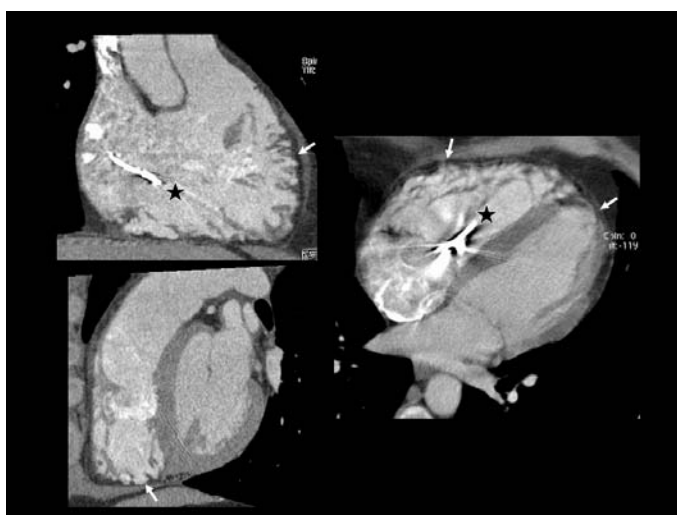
Arrhythmogenic right ventricular dysplasia (MDCT). Oblique multiplanar reconstructions demonstrate diffuse dark fatty replacement (*arrows*) of both the right ventricular myocardial wall, which also shows prominent irregularity and multiple small outpouchings, and the apical portion of the left ventricular wall. Owing to the presence of an implanted defibrillator (*stars*), MRI could not be performed
